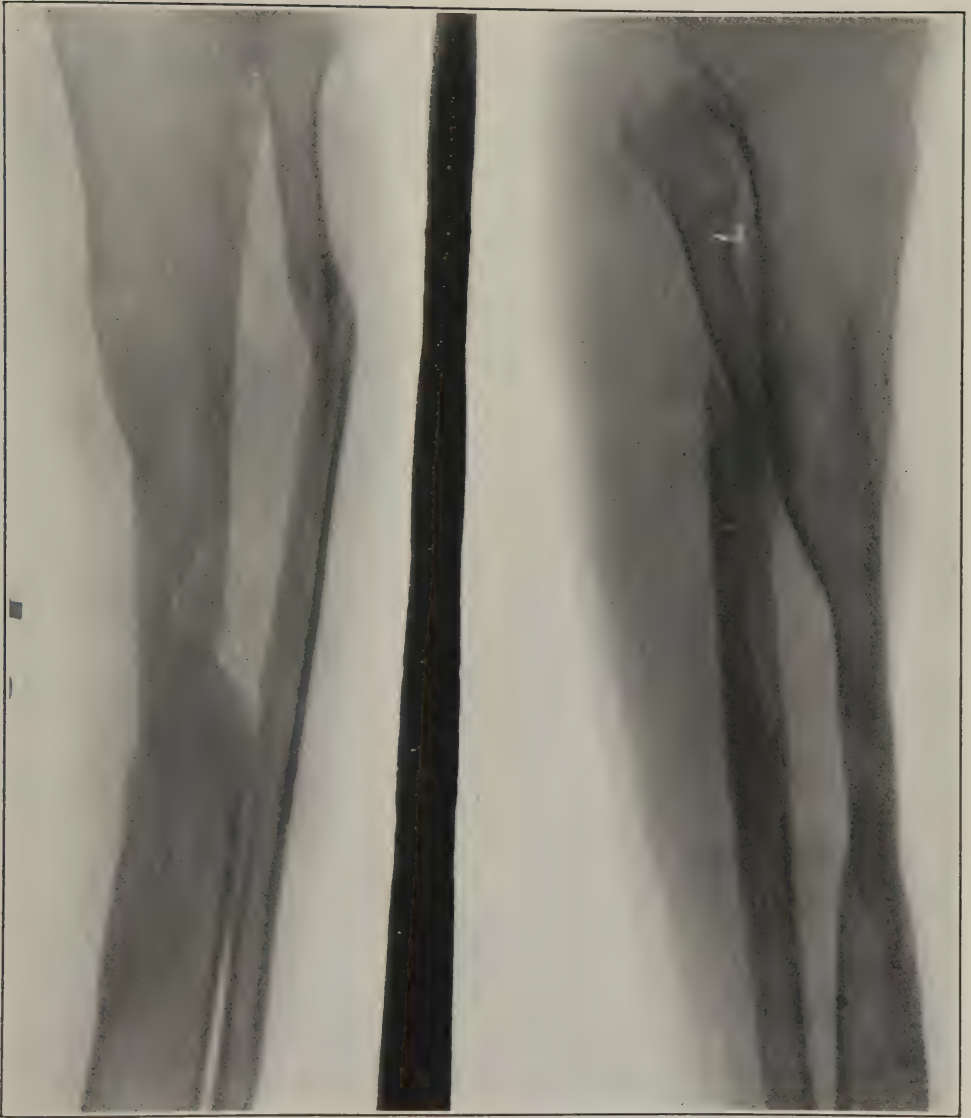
Case 1. August 1, 1922. Roentgenogram showing excellent bony union
